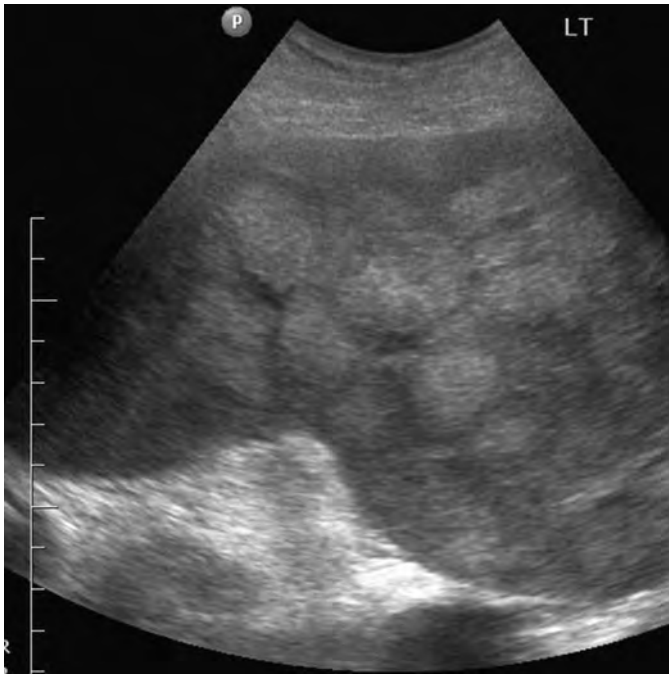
Hyperechoic splenic metastasis from melanoma. Ultrasound demonstrates multiple hyperechoic masses throughout the spleen. Multiple similar lesions were present throughout the liver (not shown).
